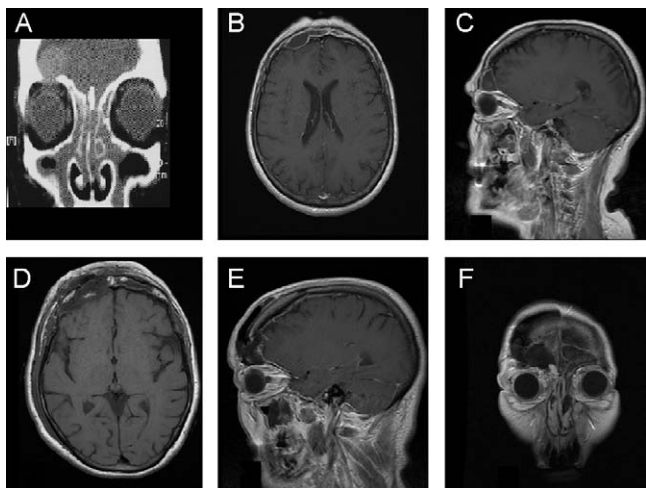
Patient #1: Pre-operative coronal CT scan (A) and contrast-enhanced axial (B) and sagittal (C) T₁-weighted MRI demonstrating a right frontal mucocoele with extension into the right orbit and the contralateral frontal sinus. Post-operative contrast-enhanced axial (D), sagittal (E), and coronal (F) T₁-weighted MRI demonstrating resection of the frontal sinus mucocoele and packing of the nasal frontal ducts with autologous fat.
